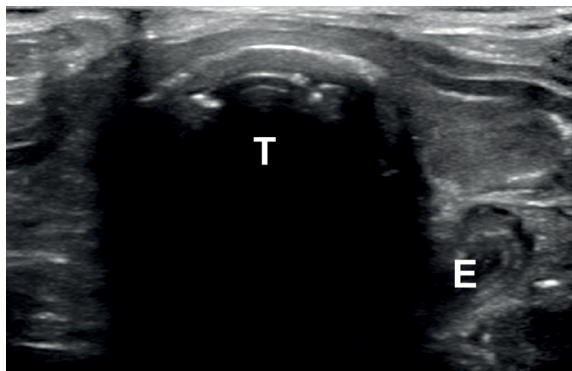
Tracheal intubation on point-of-care ultrasound. Endotracheal tube visualized as a thin, hyperechoic line behind tracheal cartilage (T) that can be enhanced by gently twisting the tube to create motion artifact. Esophagus (E) is visualized as oval muscular layers and decompressed
